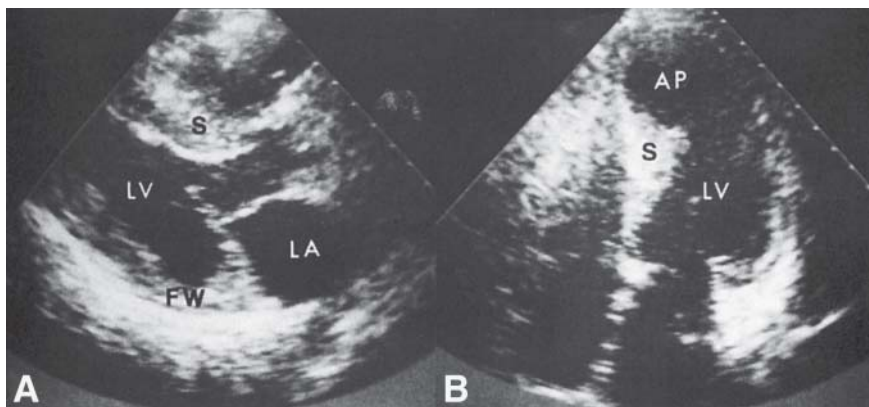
Long-axis (A) and apical four chamber (B) echocardiograms of a patient with hypertrophic cardiomyopathy whose hypertrophy primarily involves the proximal two-thirds of the interventricular septum (S). The apex (AP) is spared from the hypertrophic process. LV, left ventricle; FW, left free wall; LA, left atrium. From Feigenbaum H. Echocardiography. Fourth edition. Philadelphia: Lea & Febiger, 1986:519. Reprinted with permission.
